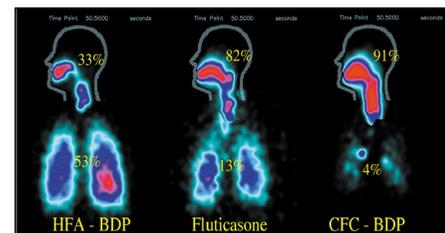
Radioscintigraphy comparison of deposition from HFA beclomethasone dipropionate MDI to two CFC MDIs. (from Leach et al., *Am J Respir Crit Care Med*, 2000, 16(3):A34.
